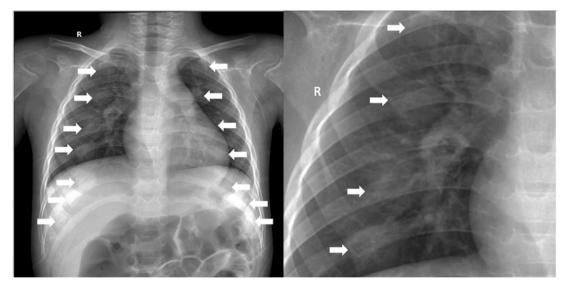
Costochondral junction expansion, or "scorbutic rosary", was seen on the patient's chest X-ray (white arrow).
